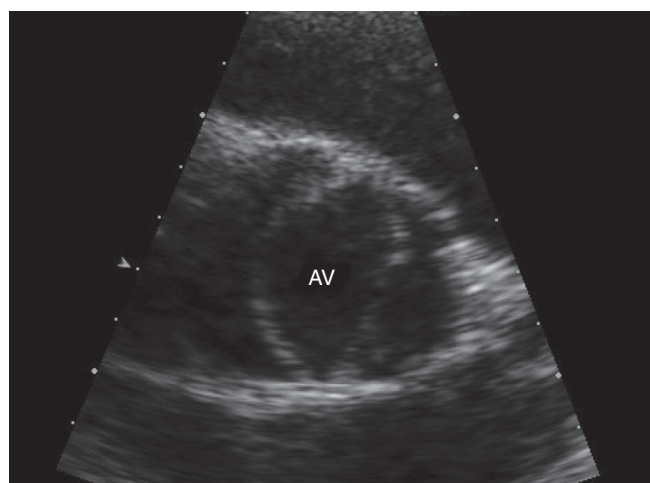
■ Parasternal short-axis view of a bicuspid aortic valve, showing a linear anterior-posterior valve opening during systole. AV, Aortic valve.
